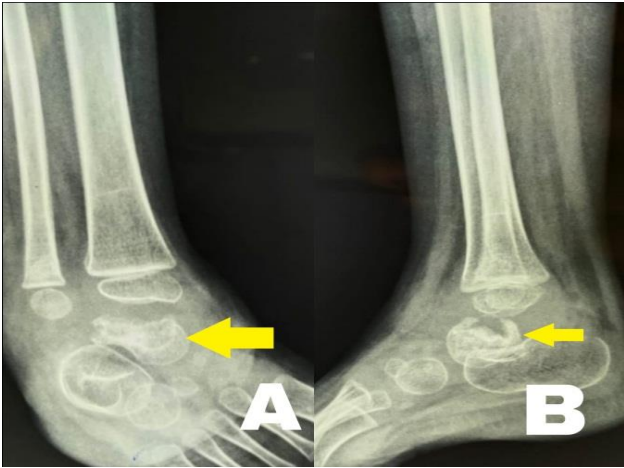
(A and B): Radiographs of the lytic lesion involving the talus with collapse.
